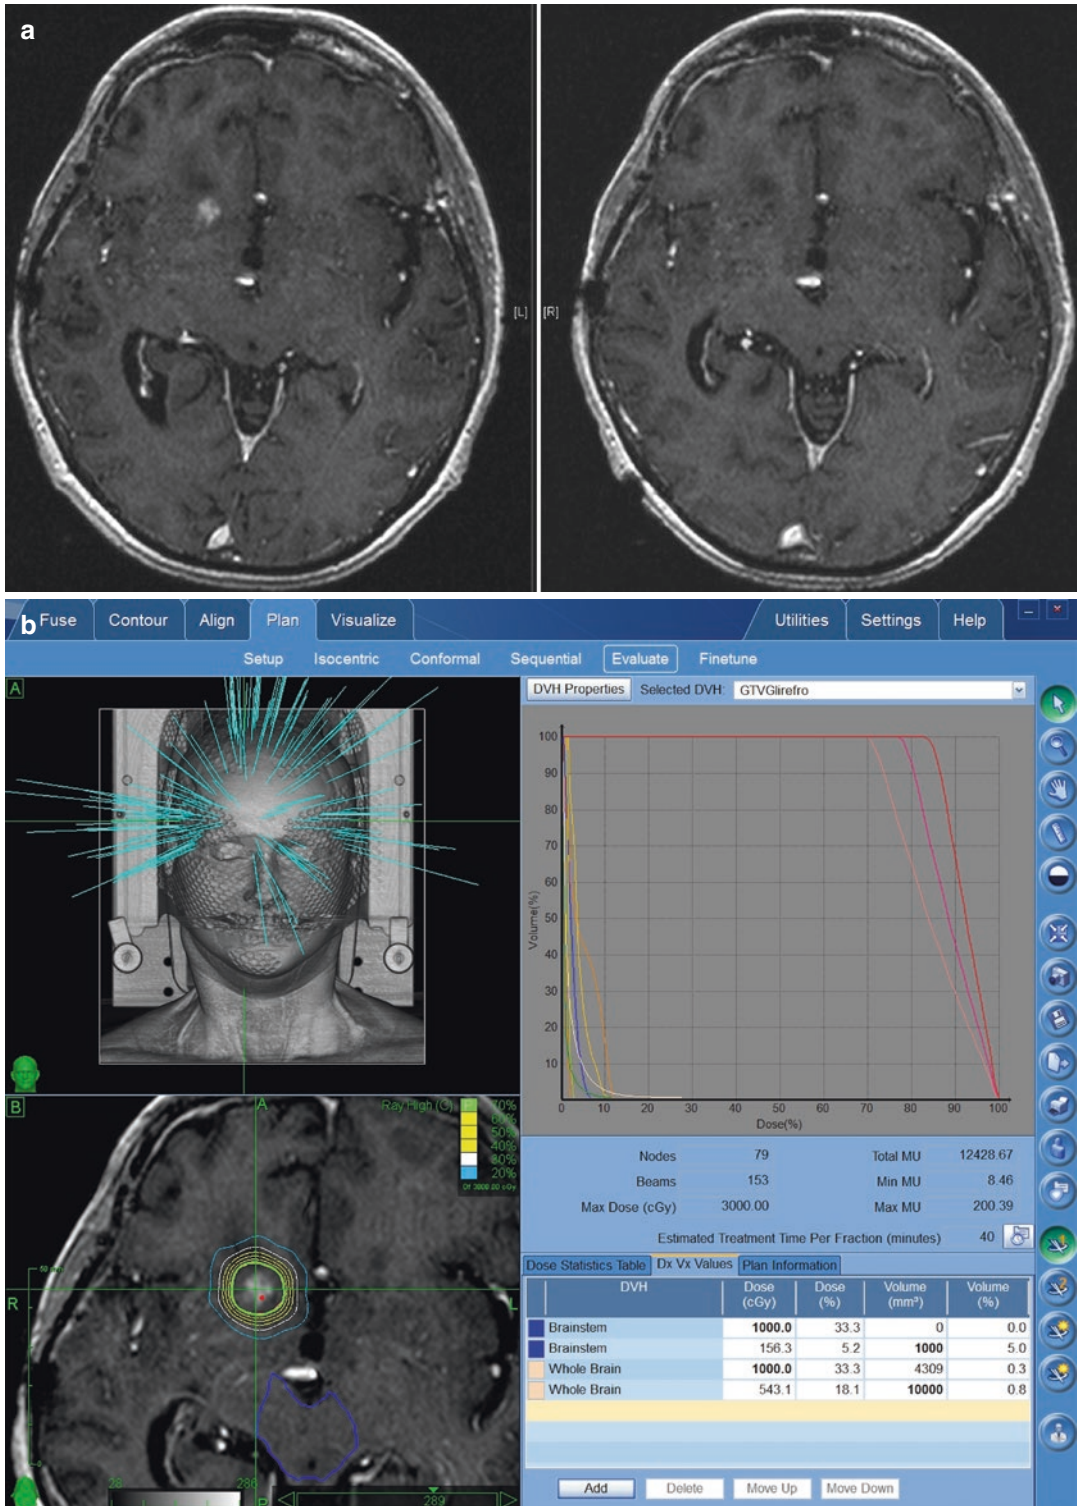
(a) *Left*: preoperative MRI of 67-year-old female diagnosed with glioblastoma multiforme (GBM) IDHwt and MGMT+ diagnosed and resected. The patient received STUPP chemoradiation until May 2017. The patient presented the small recurrence showed in the MRI scan in May
